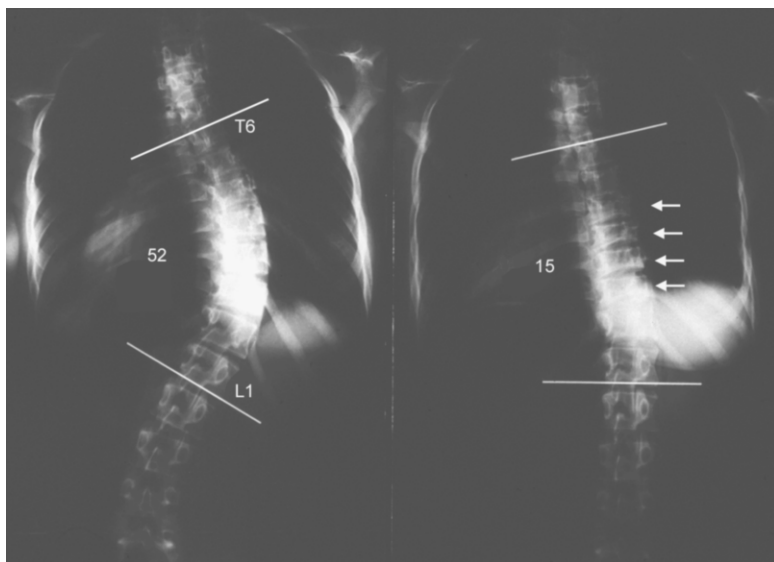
Standing posterior-anterior radiographs of a 17-year-old female before surgery and two years after wedge osteotomies on T8, 9, 10 and 11 (arrows). Curve from T6 to L1 was reduced from 52° to 15°.
